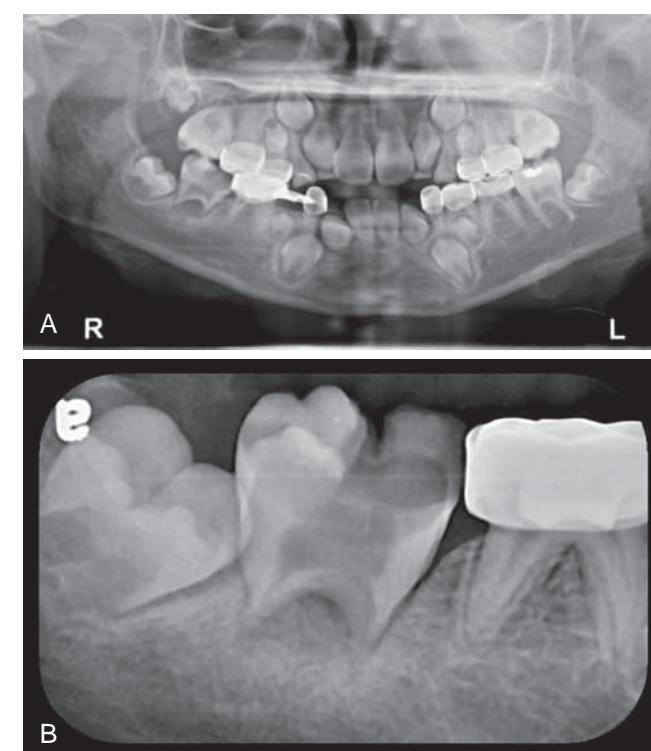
Late effects of chemotherapy. (A) Panoramic radiograph of a survivor of high-risk neuroblastoma showing arrested, blunted roots. (B) Periapical radiograph of the same patient highlighting the blunted roots. (Courtesy Dr. Terry Vik.)
